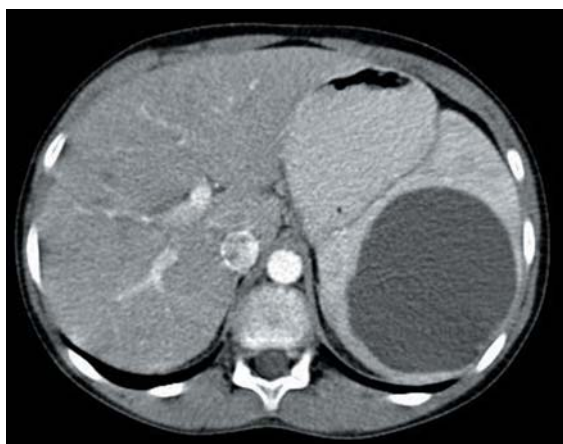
CT scan of Case 3 revealing epidermoid cyst (7 x 8 cm) located centrally.
